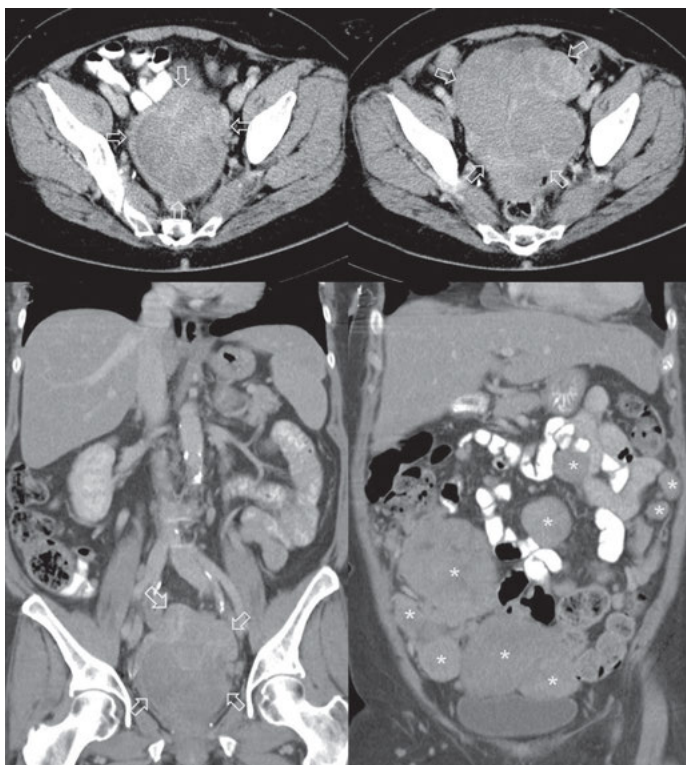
64-year-old patient with pleomorphic rhabdomyosarcoma of the uterus. Axial and coronal abdominal CT in the portal venous phase (top and bottom left) reveal a knotty, nodulated tumor, with inhomogeneous contrast agent enhancement (arrows), that originates from the uterus and that extends far into the vagina (8 × 9 × 11 cm); two months later (top and bottom right), the primary tumor had grown substantially (14 × 11 × 13 cm) and peritoneal metastases could be observed (stars).
